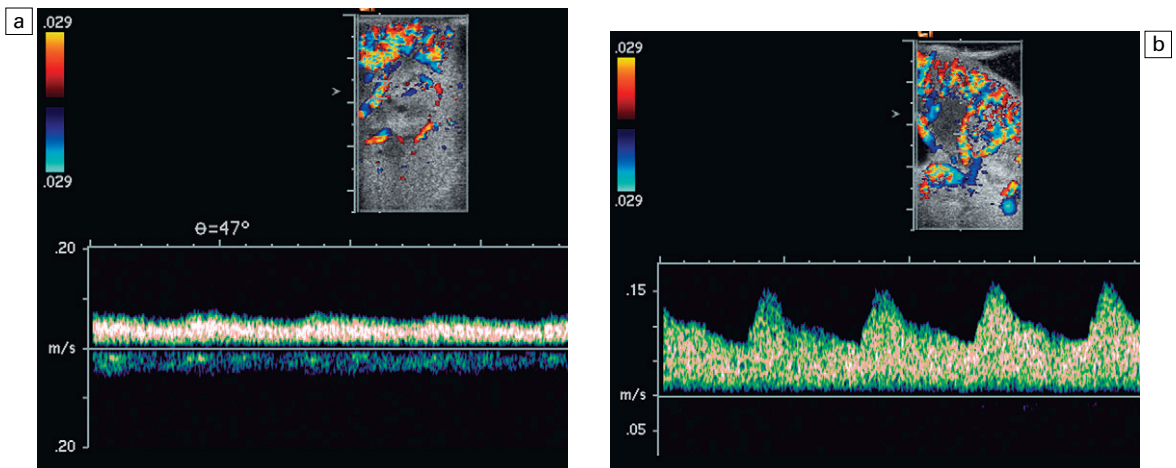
Intraoperative spectral and colour Doppler ultrasound of a recent renal transplant recipient being reoperated because of non-function and a Doppler suggestion of arterial stenosis. This spectral Doppler tracing of a segmental artery and its adjacent vein shows only a very subtle undulation in the arterial waveform (towards the transducer). The severe proximal stenosis completely wiped out the expected systolic velocity variation. The tracing below the baseline is not mirror imaging of the tracing but venous outflow. (b) As the anastomosis was surgically manipulated a sudden increase in arterial velocity with a more conspicuous arterial tracing became evident on spectral Doppler.
